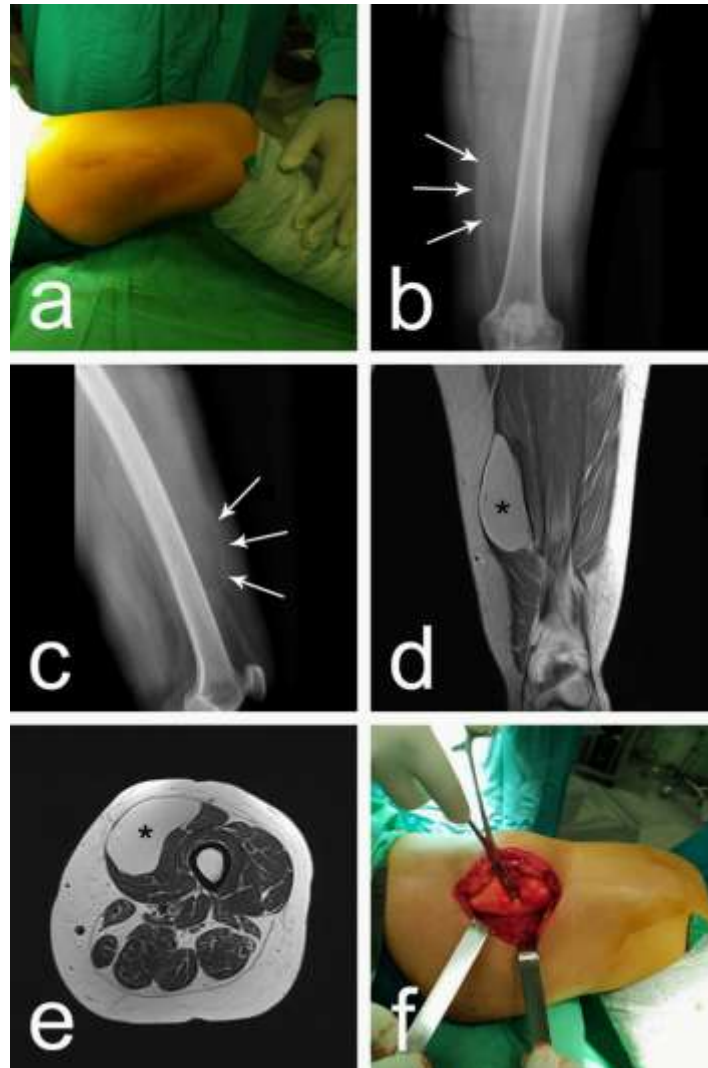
a) Preoperative photography; b, c) Preoperative AP and lateral radiographs of the left thigh showing a well-delineated radiolucent mass (arrows); d) Coronal T1-weighted MRI scan demonstrating a homogeneous, hyperintense mass located within the vastus medialis muscle (asterisk); e) Axial T2-weighted MRI demonstrating the mass located within the vastus medialis muscle (asterisk); f) Intraoperative photography.
